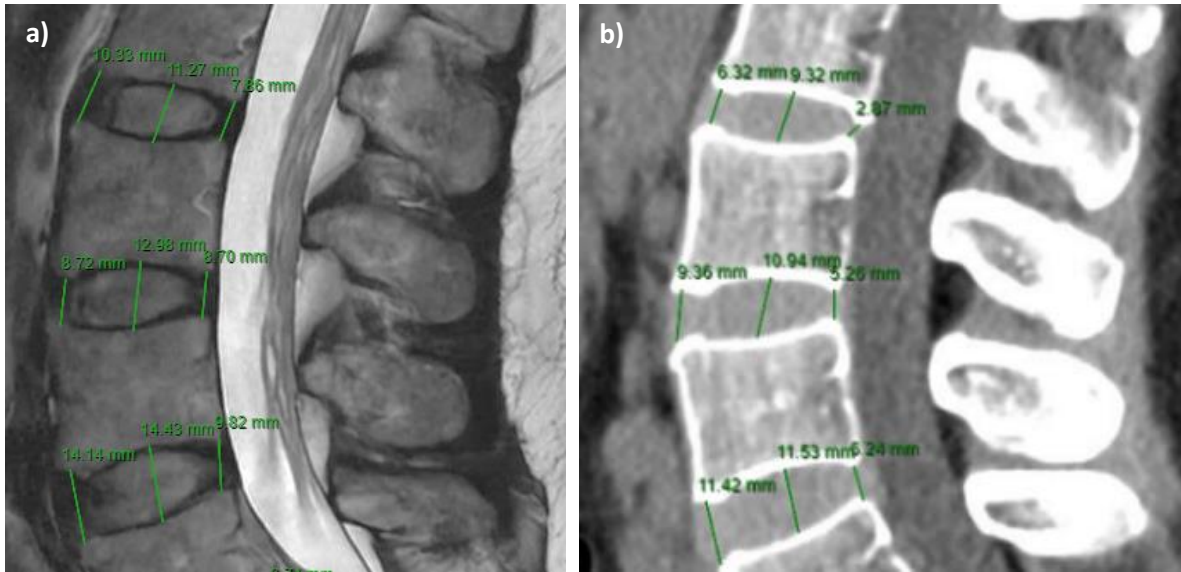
Comparison of “IVD height” parameter in different imaging modalities a) MRI and b) CT, of patient HLS.055.
